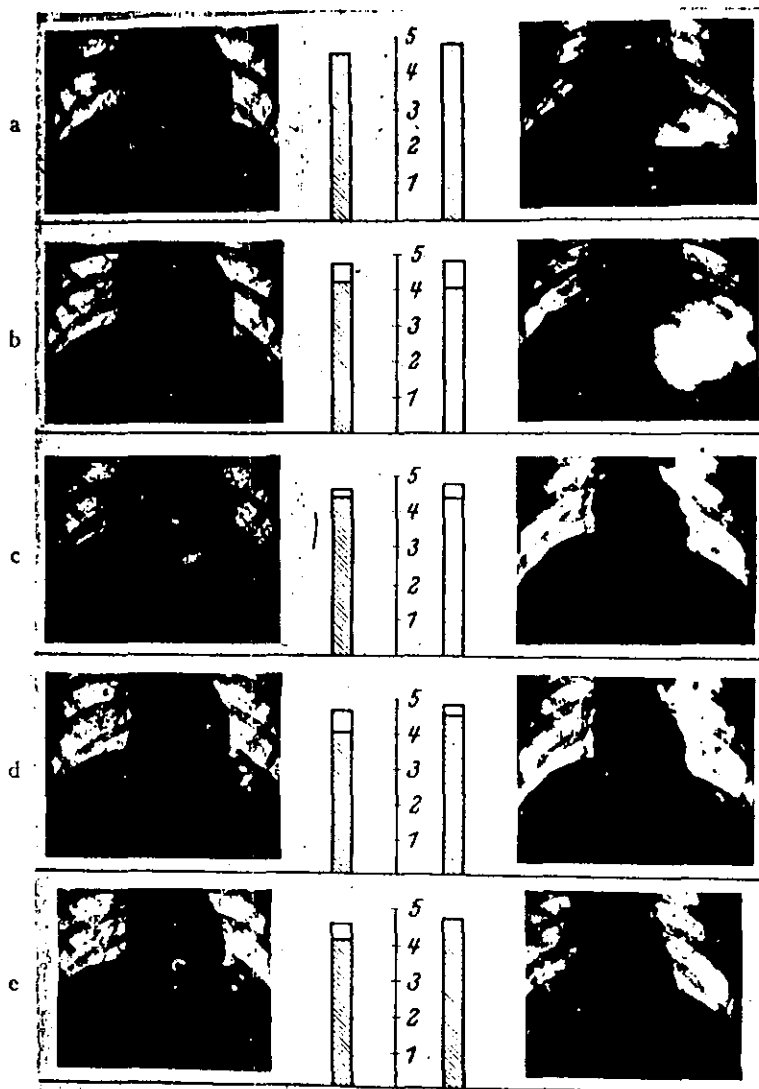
Position of diaphragm (X-ray photograph) and vital capacity (in liters) in two test subjects during a 70-hour experiment at 9,000 m. (29,500 ft.) altitude with 82%  $O_2$ . The white fields above the hatched columns of the vital capacity correspond to the deficit as compared to the initial value at zero meters.
